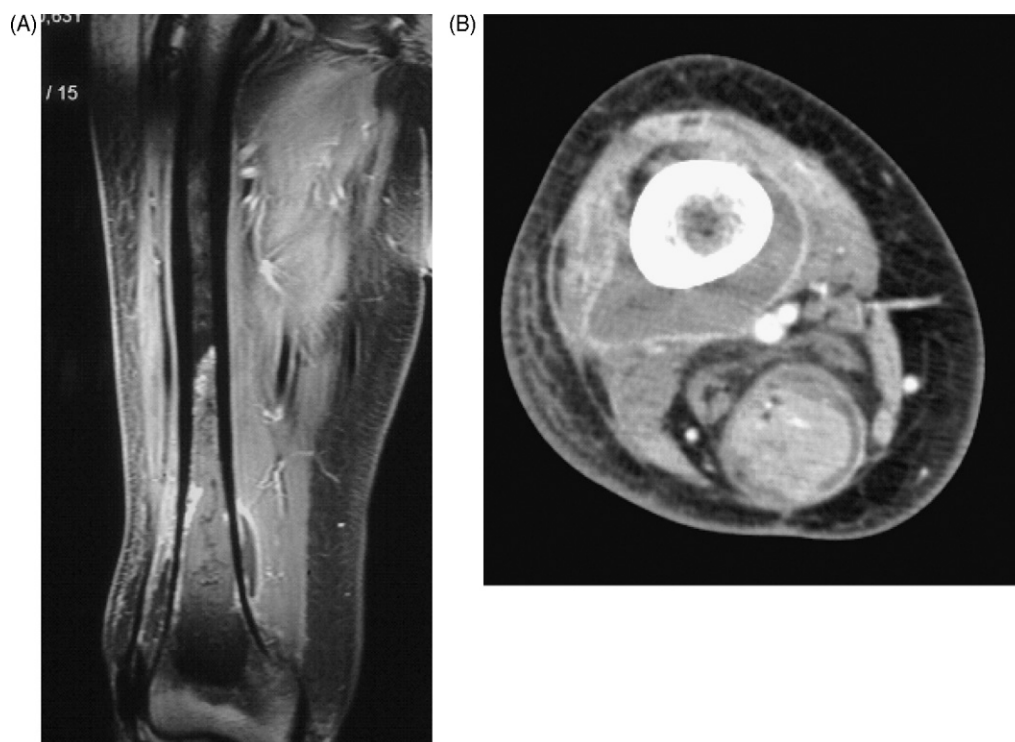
MRI scan of the femur, showing (A) the extent of *Salmonella* osteomyelitis within the distal femur, and (B) periosteal and submuscular abscess formation.
